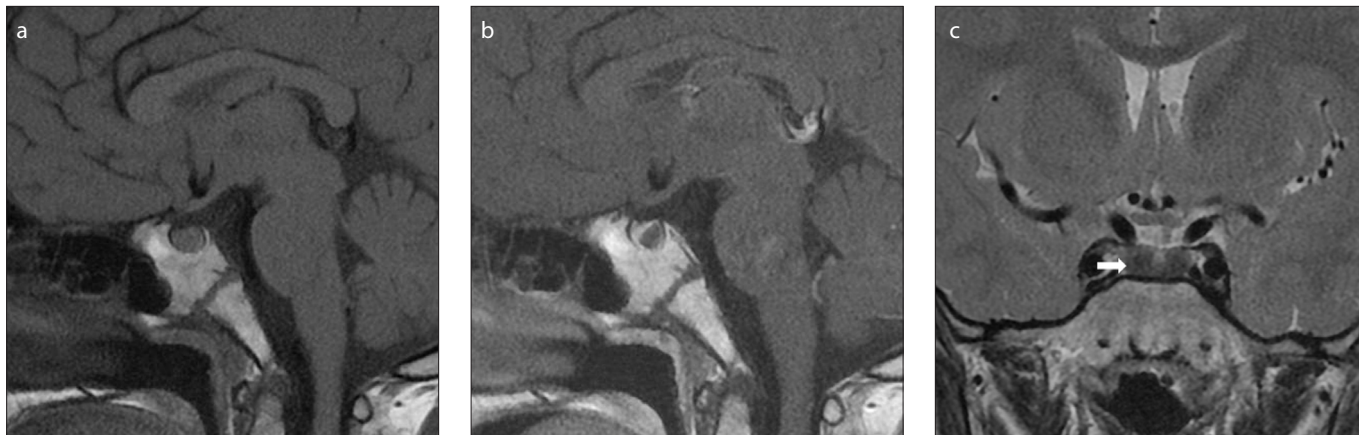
a–c. Sagittal pre- and postcontrast T1-weighted (a, b) and coronal T2-weighted (c) images show a subcentimeter size, nonenhancing RCC that is located between anterior and posterior lobe of the pituitary. The RCC is isointense to the anterior pituitary gland on sagittal unenhanced T1-weighted image (a) and hypointense on sagittal contrast-enhanced T1-weighted (b) and coronal T2-weighted image (c, arrow).
